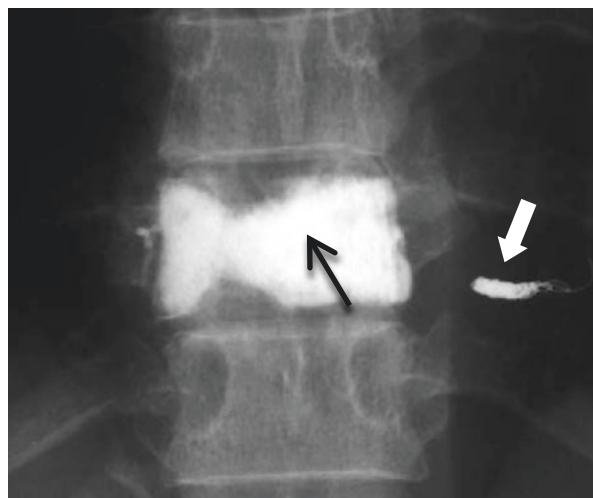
AP follow-up radiograph of same patient post D8 hemangioma embolization and percutaneous vertebroplasty PMMA cementing material, highly radiopaque, entirely filled the hemangioma (*black arrow*); in the left paravertebral side is highlighted (*white arrow*) the employed coil for the pre-vertebroplasty embolization
